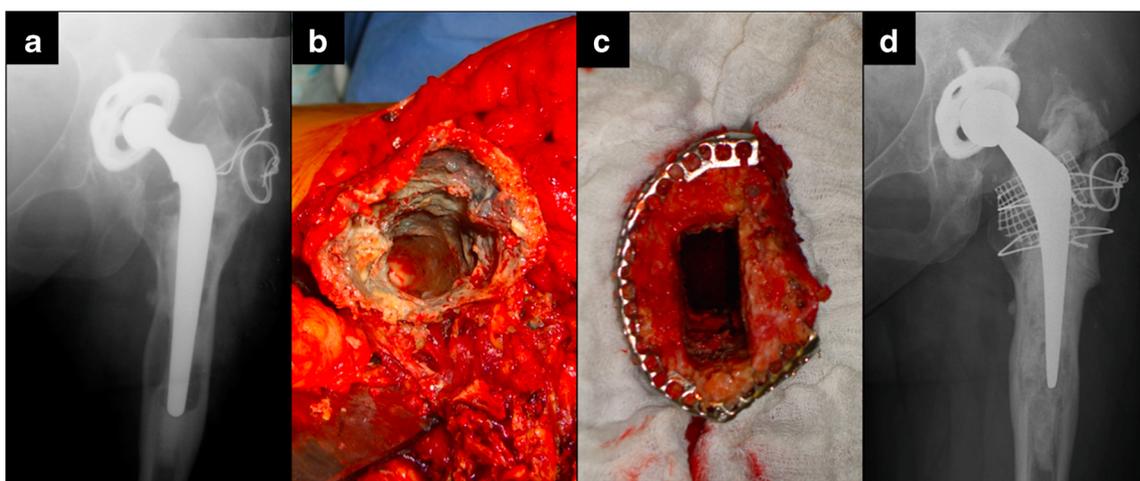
a Post-operative radiograph of the 52-year-old female's left hip with a cemented Chamley Straight Narrow Stem (SNS) at 9 years following the surgical treatment of a dysplastic coxarthrosis. Well-circumscribed tumour-like lesions are visible at Gruen's zones 2, 3, 5 and 6. b Intra-operative image after prosthesis and cement extraction
